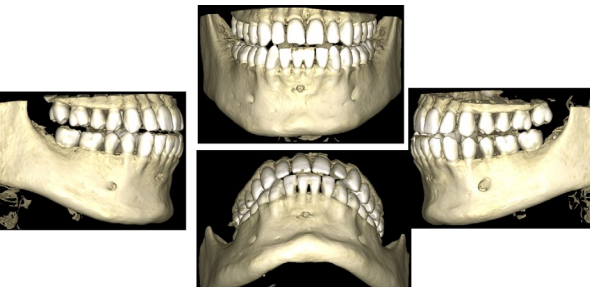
15 months CBCT follow-up
